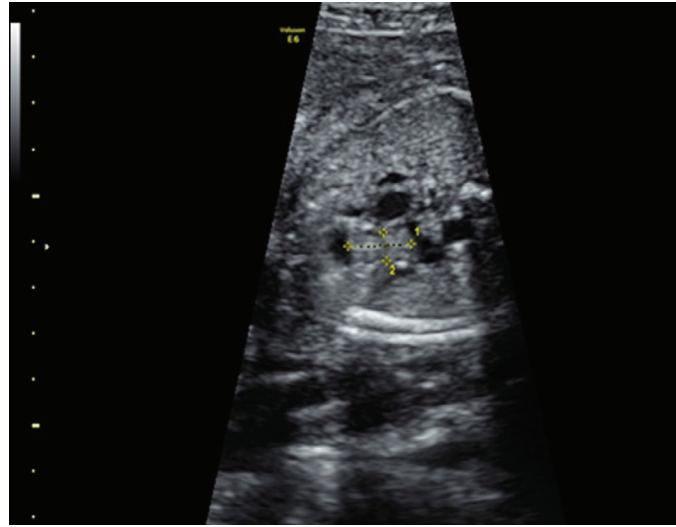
Ultrasonographic image of the mass
